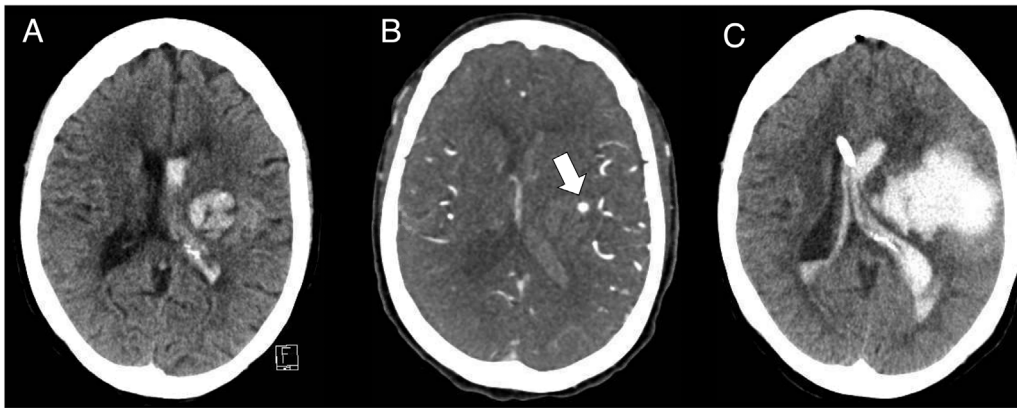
Early CT signs of active bleeding: the spot sign. (A and B) The initial CT scans of irregular intracranial bleeding on admission to hospital. The point-like extravasate of contrast agent (“spot-sign”; marked with an arrow in B) indicates the active bleeding at the time of the examination. (C) Progression 6 hours after admission. (CT images were provided by Dr. med. Jörg Poggenborg, Head of the Department Neuroradiology, Cologne-Merheim Medical Centre.)
